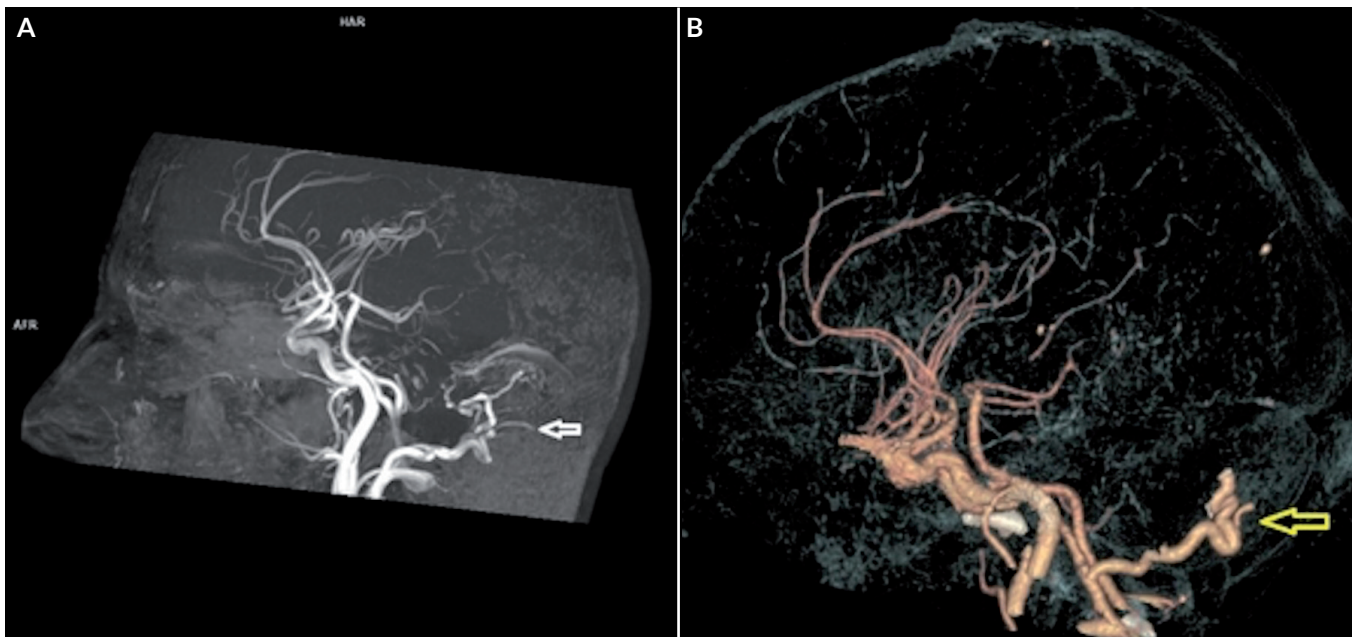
Angio-MR and CT angiogram scans. A. Image of an arteriovenous fistula in the sagittal plane in the maximum intensity projection (MIP) of an angio-MR (time of flight) TOF examination. B. Dilated, tortuous left external carotid artery in a virtual reality (VR) reconstruction of a CT angiogram
